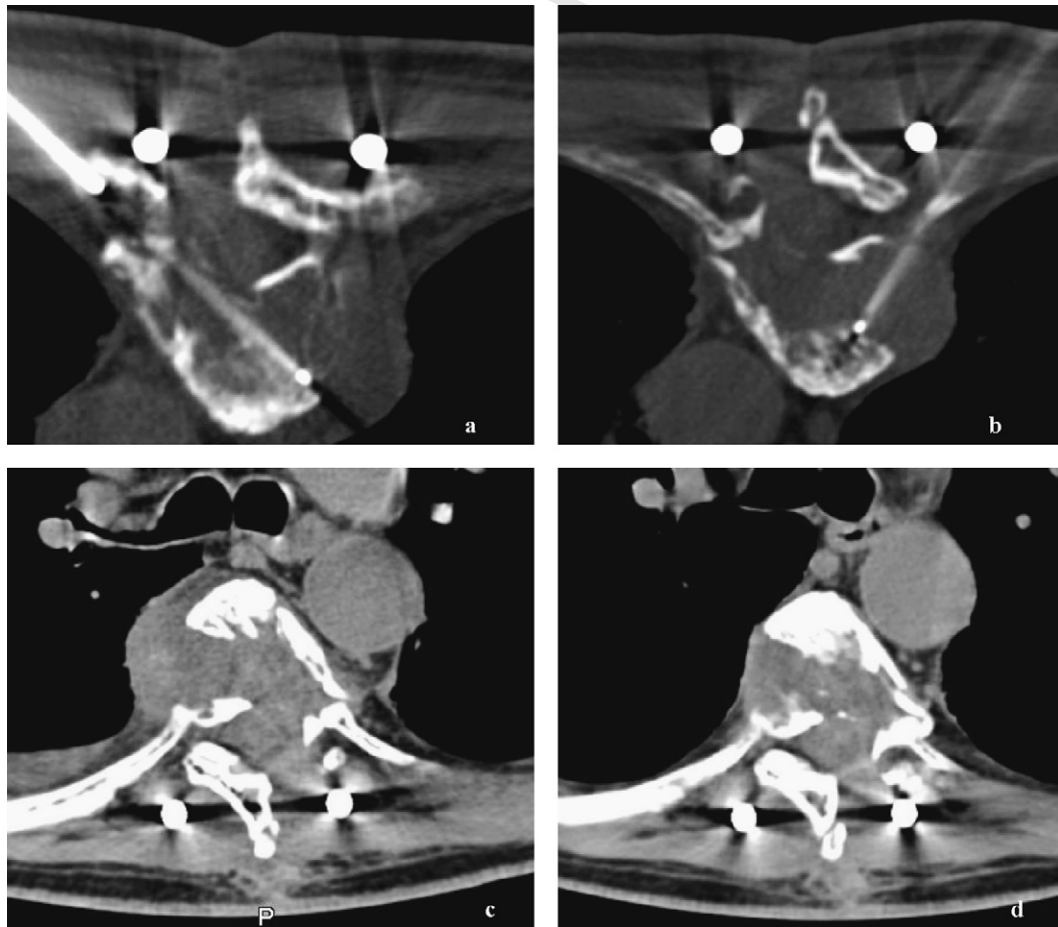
Case report #2. This 59-year-old patient suffered from renal cell carcinoma metastasizing into vertebrae T-6 and T-7. Dorsal decompression of T-6 and dorsal stabilization of T-4–T-9 had been performed prior to the patient’s presentation at our institute with tumor progression, pain, and signs of paraplegia. RFA was performed in T-6 and T-7 (slides a and b). Repeat CT was not suggestive of tumor progression at the intervention sites up to 9 months later (slides c and d). Because of spondylolysis, MRT was not performed. The patient regained mobility and experienced regression of paraplegia signs.
